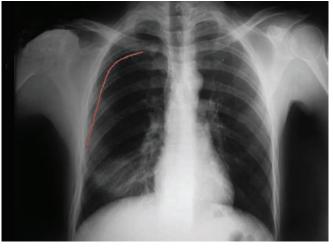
Chest X-ray: Pneumothorax identified in the left image
